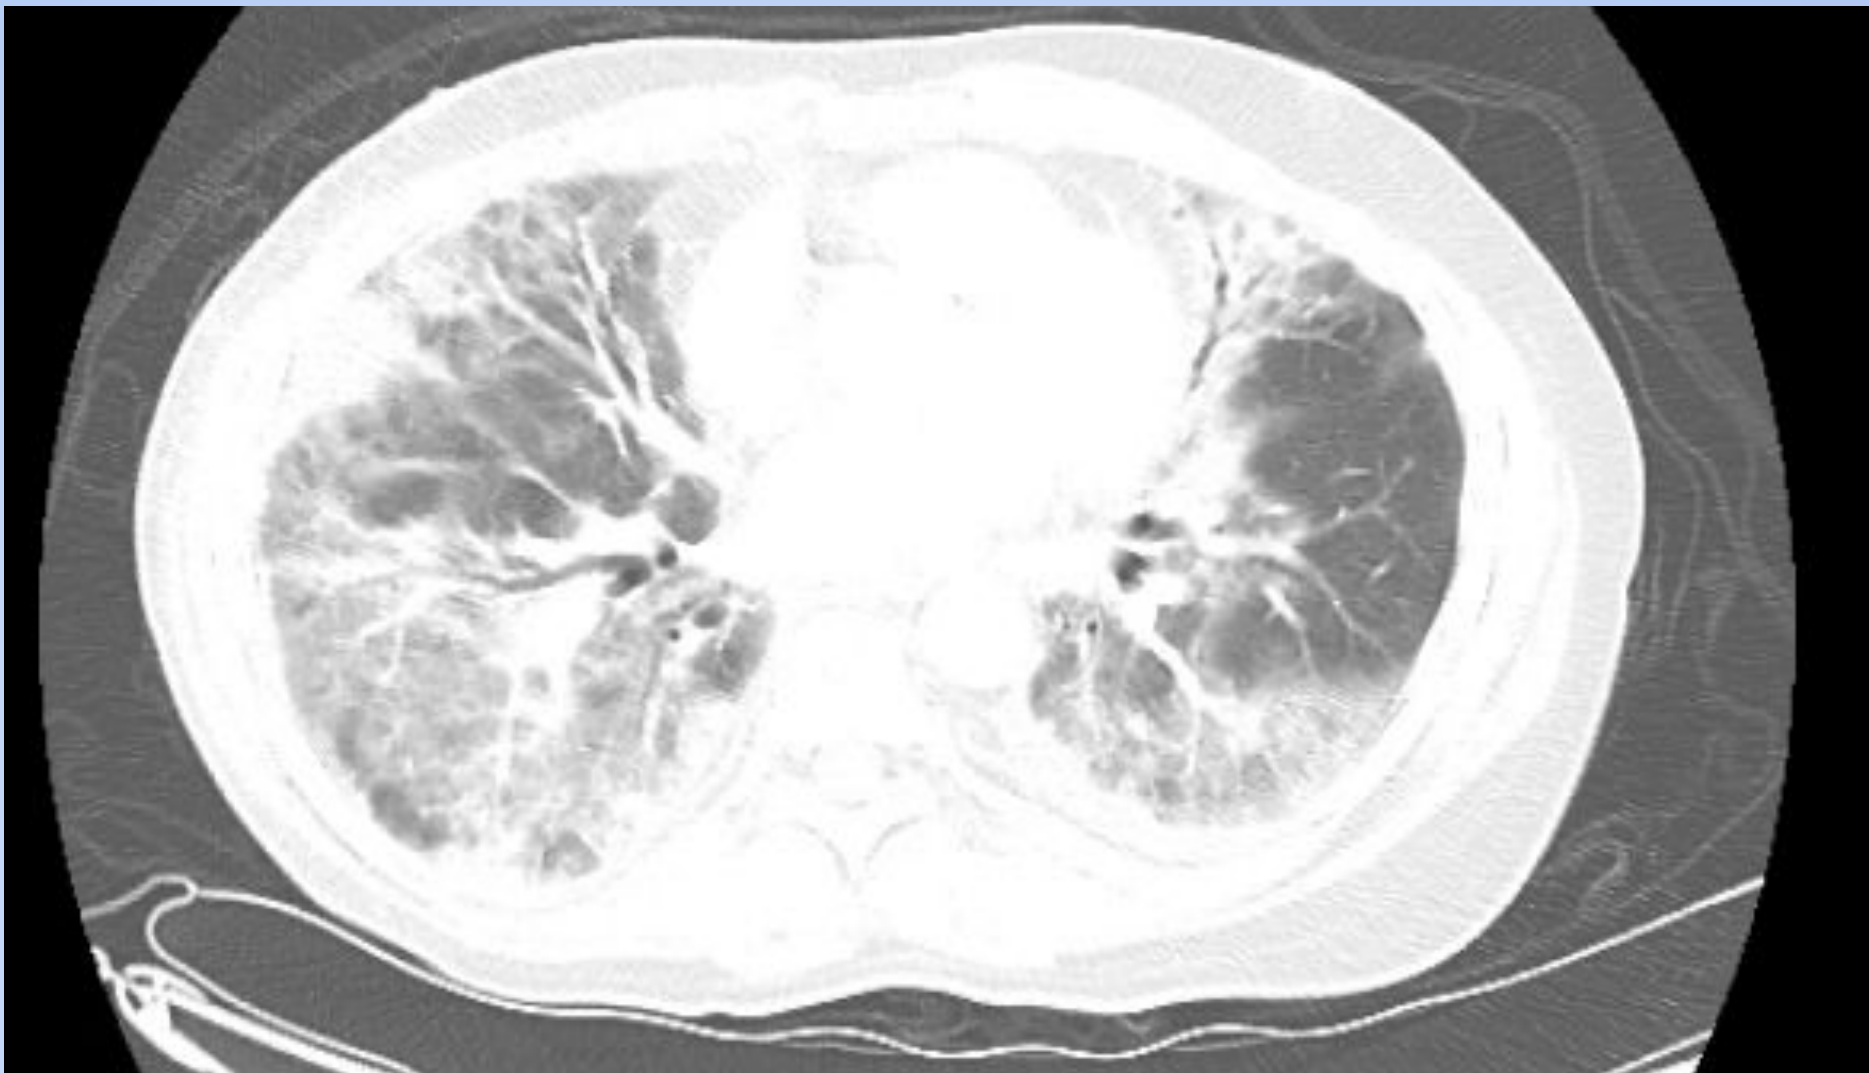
CT chest during first admission
